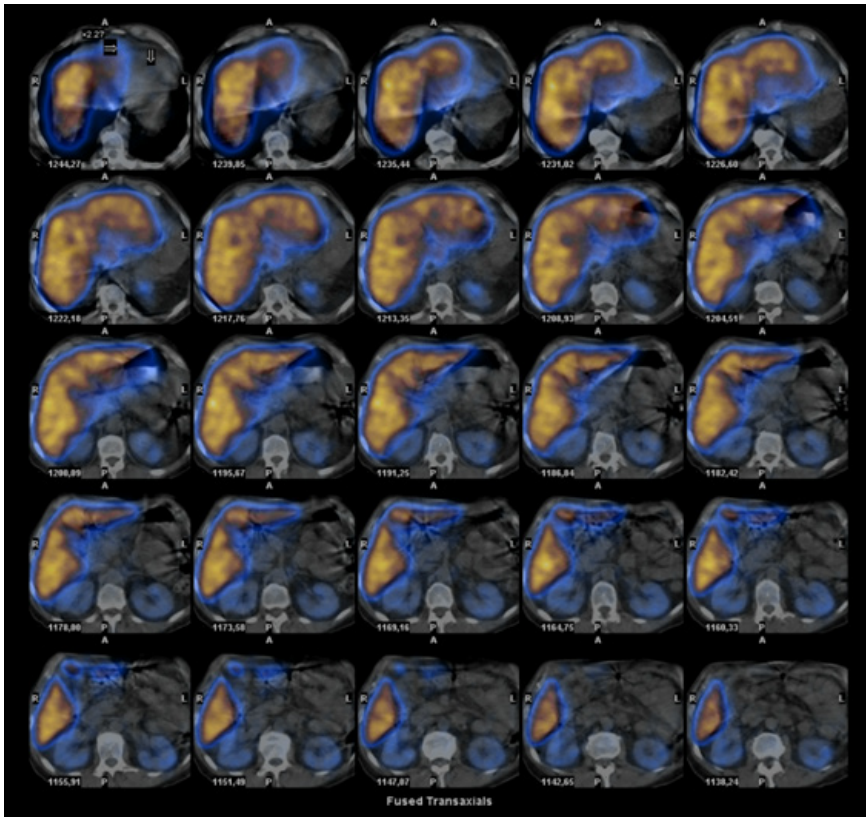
SPECT-CT fusion images of the abdominal region- liver uptake was globally homogenous with no focal uptake at the site of the lesions depicted on MRI.
